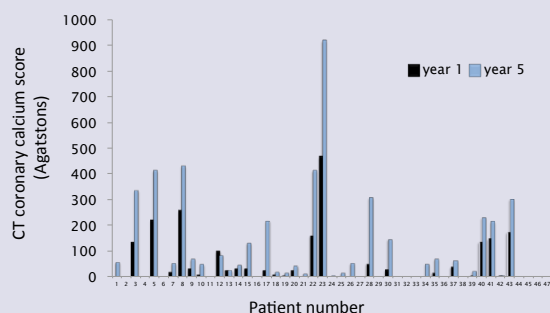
CT coronary calcium scores for 47 patients at year 1 and at year 5
